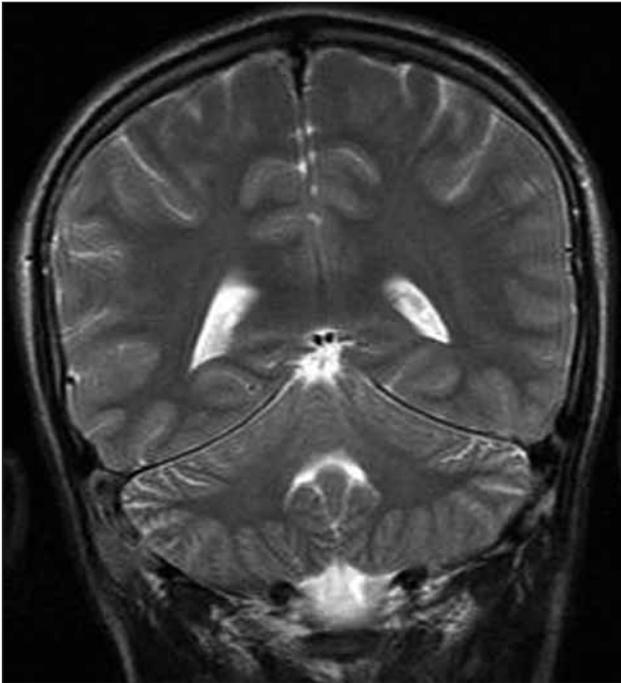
T2-weighted coronal image showing clearing of the subdural empyema and significant decrease in ventricle size at two years follow up MRI.
